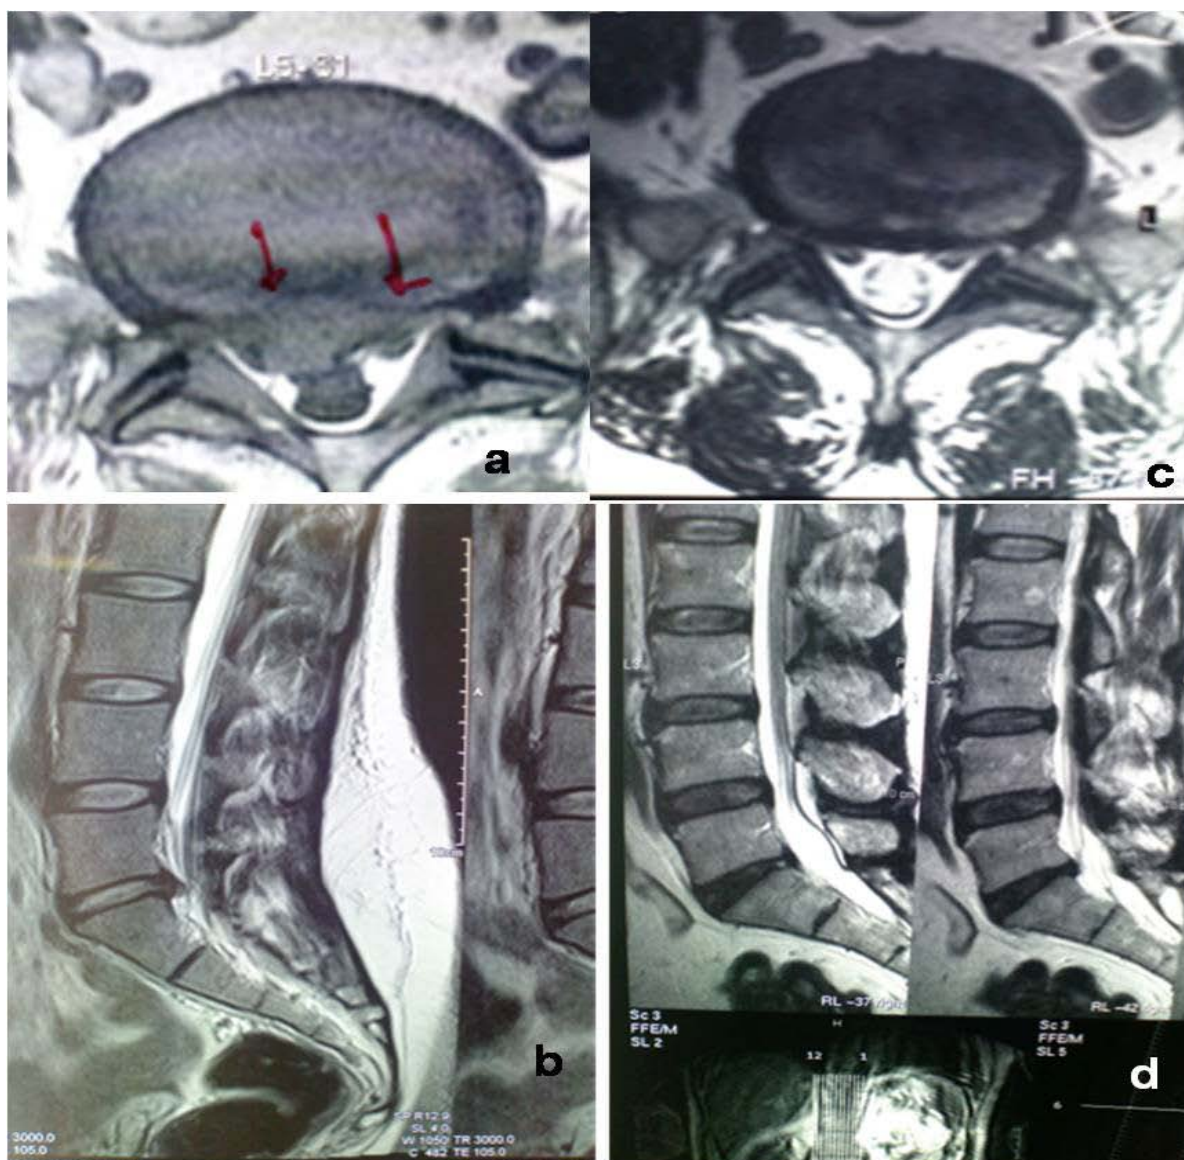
a and b- preoperative MRI of the patient with L4 and L5 prolapsed intervertebral disc. c-d post operative MRI axial and sagittal cuts showing resorption of the disc.
